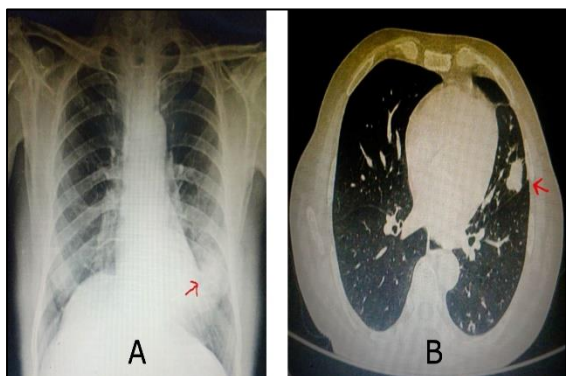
(A) Chest X-ray Showing homogenous opacities over the left lower zone (red arrow); (B) CT thorax showing a subsegmental peripheral soft tissue density (red arrow).
